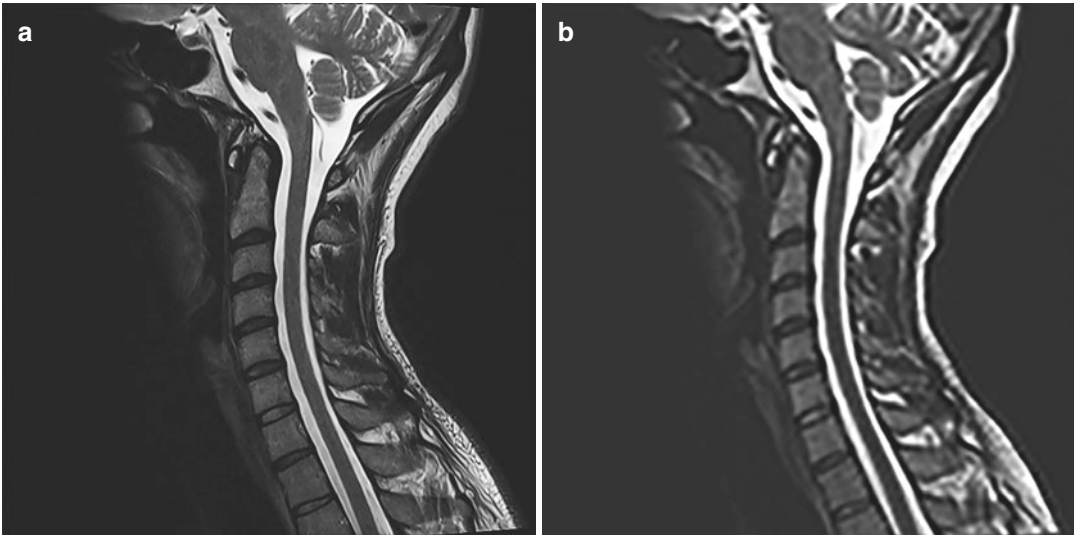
An example of a high-resolution MRI image (a) compared to a low-resolution image (b), in which discerning small structures is difficult
